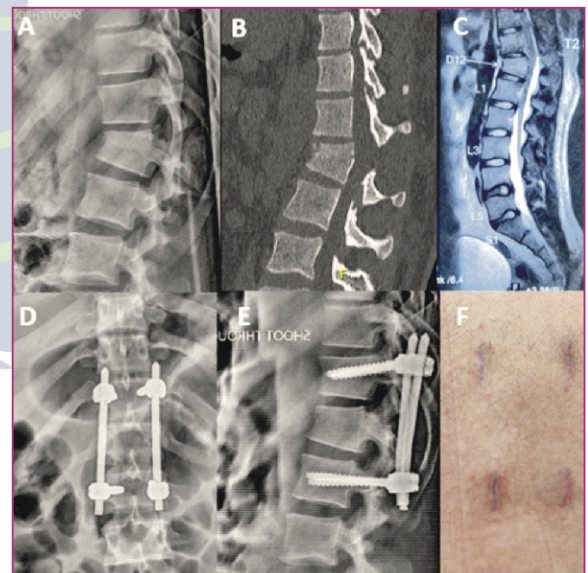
(Trauma): Case of 24-year-old that presented with a flexion distraction injury and T12 burst fracture; Fig. A : (X-ray), Fig. B (CT scan) & Fig. C (MRI)- Mid-sagittal showing flexion-distraction injury of T11 posterior elements and a T12 burst fracture, Fig. D and E - Post-operative AP & lateral X-ray of thoracolumbar spine, Fig. F - Clinical photograph displaying the scars.
